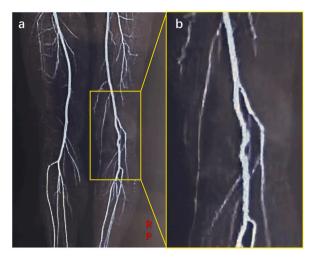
Images of CTA 4 months after surgery. (a-b) The angiography results showing unobstructed bloodstream in the right popliteal artery.
